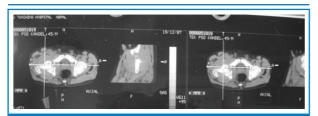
CT Scan of the hip with erosion of femoral head and acetabulum.
